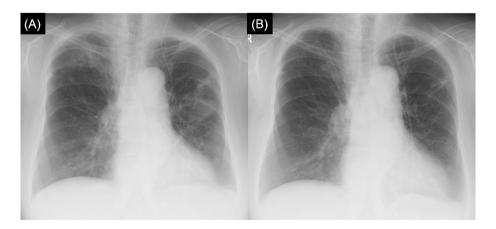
Chest radiographs. (A) Infiltration shadows are seen in the right upper and left middle lung fields during exacerbation of allergic bronchopulmonary aspergillosis. (B) The infiltration shadows are reduced after 2 weeks of treatment with dupilumab.
